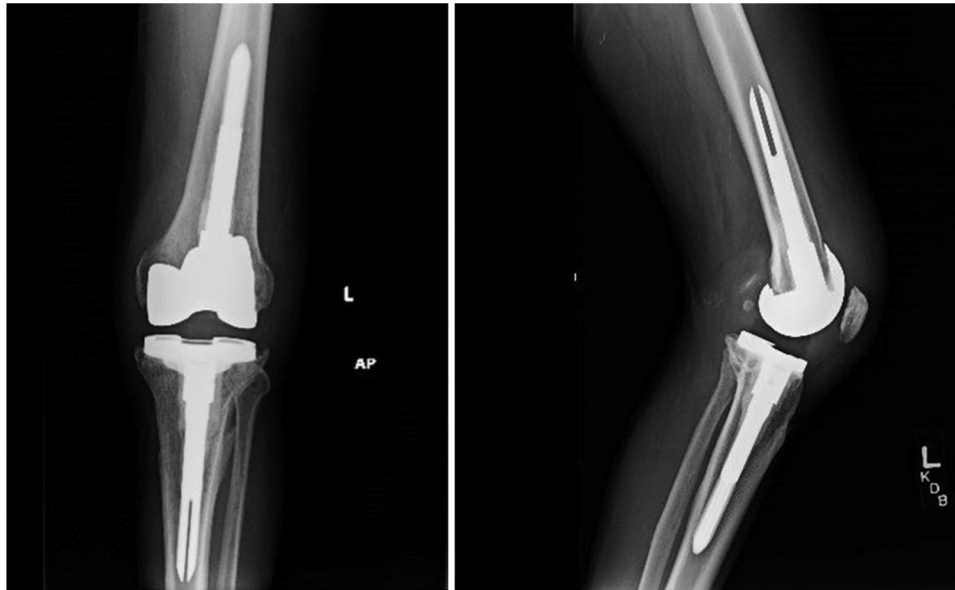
Anteroposterior and lateral radiographs following revision surgery.
